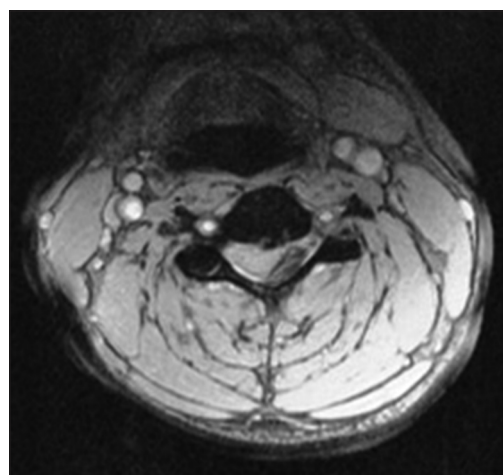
Axial T2-weighted scan of the cervical spine revealed a left dorsolateral hypointense epidural collection with compression of the spinal cord suggestive of acute epidural hematoma
